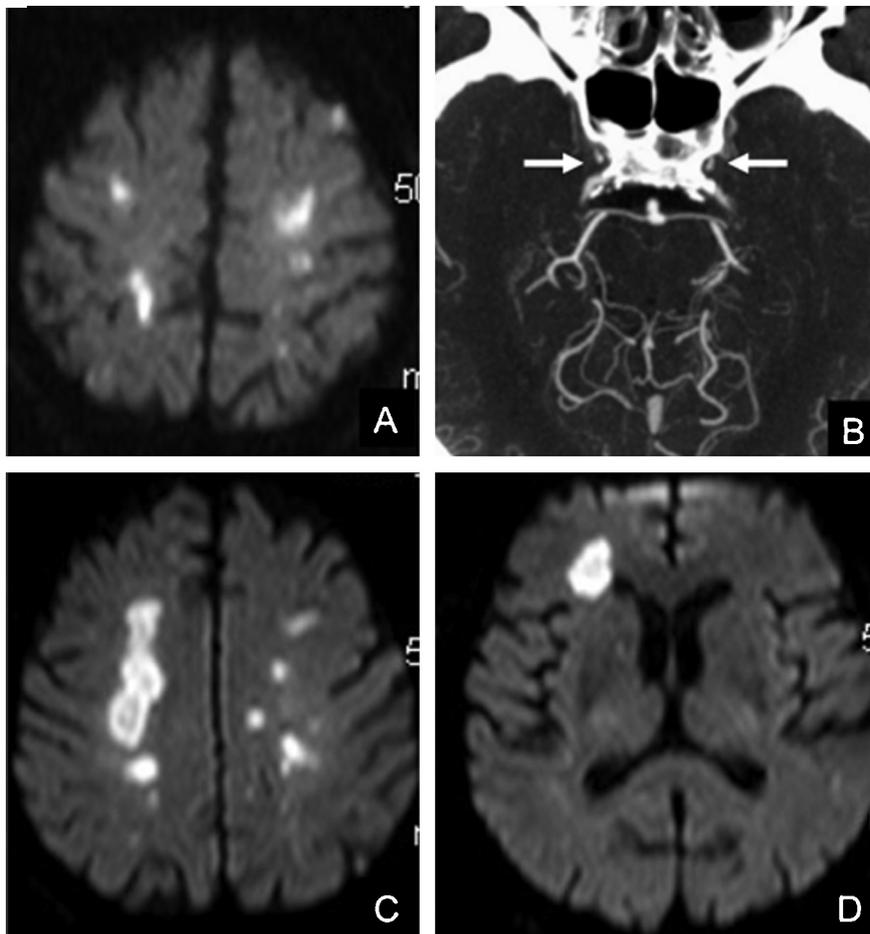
A. Axial diffusion-weighted cerebral MRI demonstrates acute multiple, bihemispheric and small cerebral infarcts. B. CT angiography reveals pre-occlusive stenoses of both internal carotid arteries located in the siphons (arrows). C and D. New axial diffusion-weighted cerebral MRI, 2 weeks after the first one, shows new and larger ischemic lesions.
